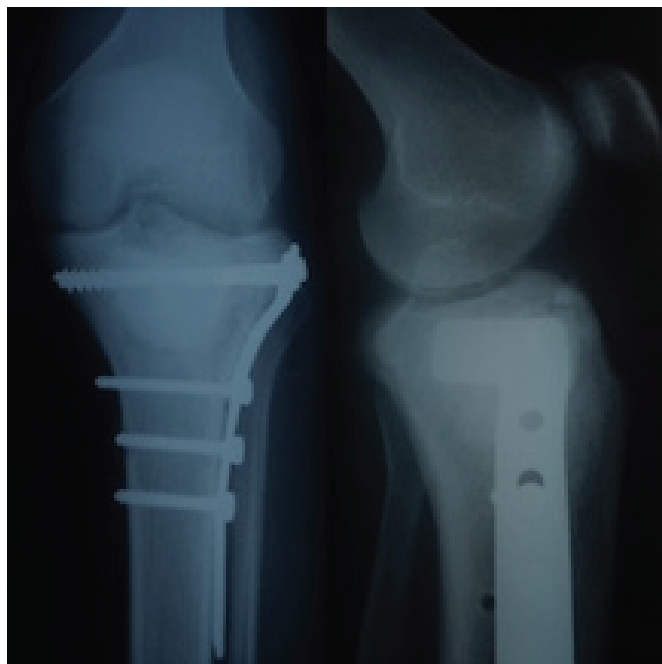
Postoperative radiographs, anterior posterior and lateral views showing polymethyl methacrylate cementoma and subchondral grafting with buttress plate *in situ*.
